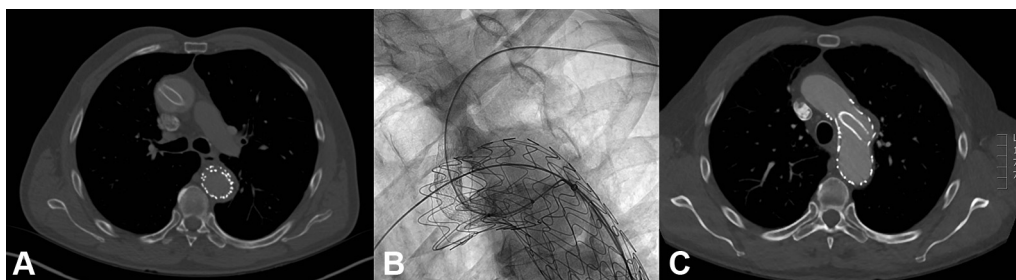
(A) Plain CT showing a chimney in the left subclavian artery in contact with the ascending aorta. (B) Intra-operative view of the configuration change from chimney to periscope. (C) Plain CT after configuration change.
